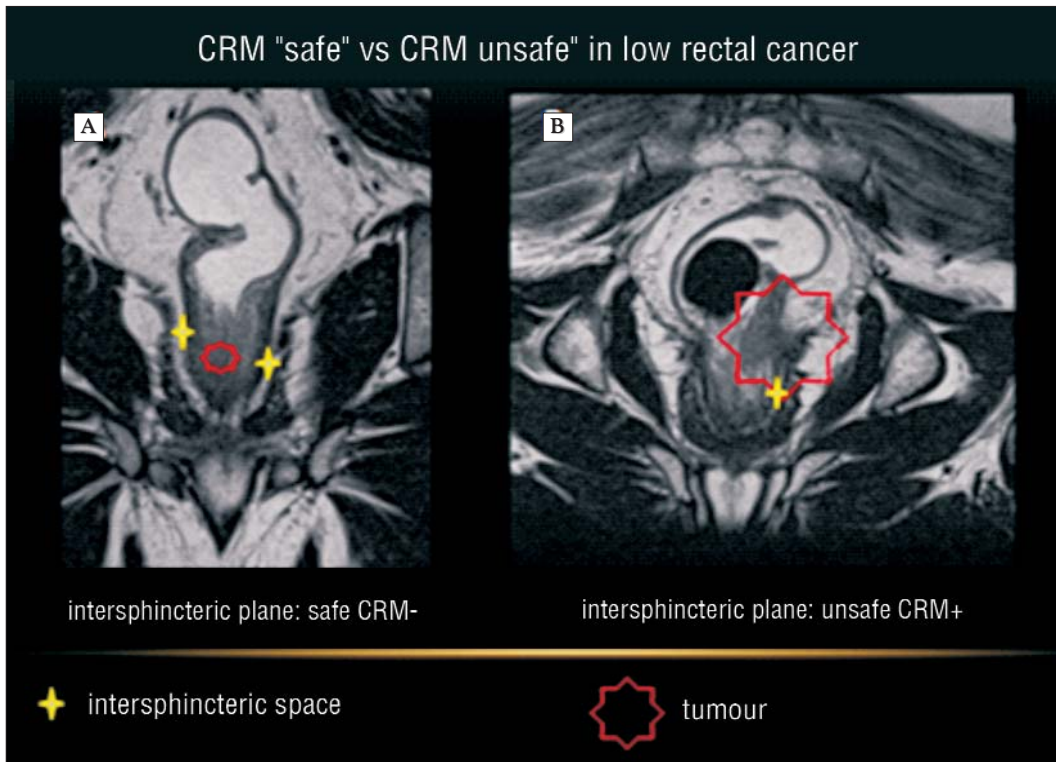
Tumour in the low rectal segment. (A) The exterior margin of muscularis propria (the black strip) is safe in both sides. Hence the intersphincteric space (the yellow star) is safe and a sphincter-preserving resection can be performed. CRM - (B) Muscularia propria, the mesorectum and the levator ani muscle on the left side in the 2-3 o'clock position are infiltrated. Consequently, the sphincter cannot be preserved during surgery. CRM +. In exchange, preoperative radiochemotherapy will be performed. If the treatment is successful resulting in the restaging at MRI, this will be followed by TME.
